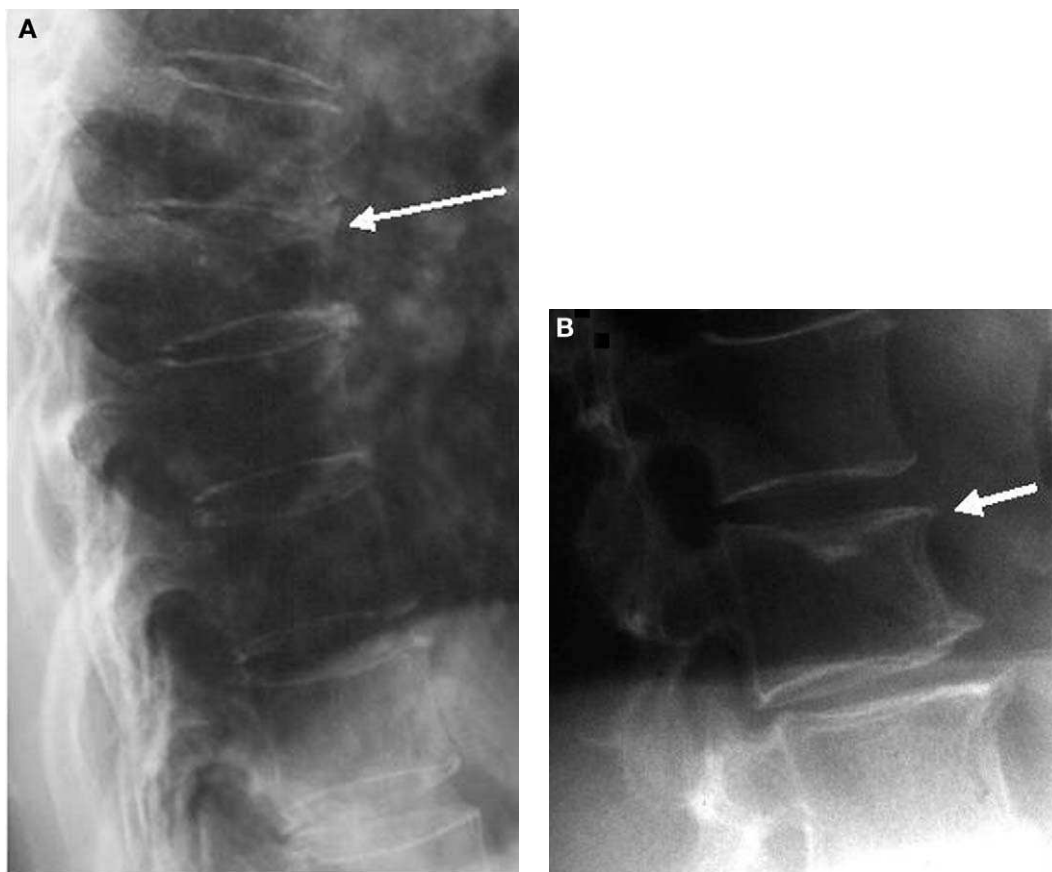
Spine radiographs. (A) Moderate grade 2 fracture of a thoracic vertebra (T9) with a height reduction of nearly 40% (arrow). (B) Grade 1 fracture of a lumbar vertebra (L2) with a wedge-like deformity and a maximum height reduction of 20% to 25% (arrow).
